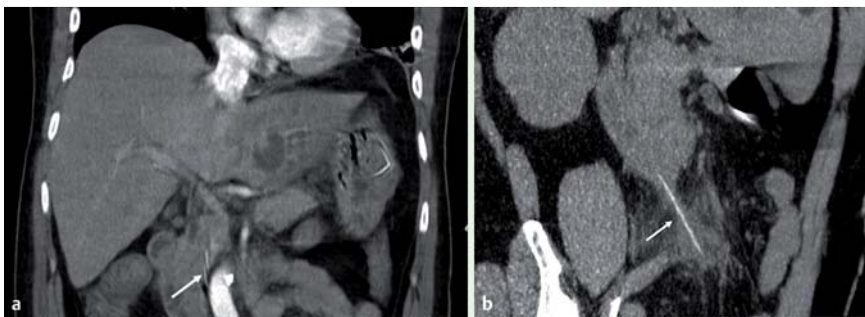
a Coronal view of reformatted CT revealed a sharp object penetrating the wall of the third part of the duodenum. b Reformatted CT image delineated the contour of the toothpick.
